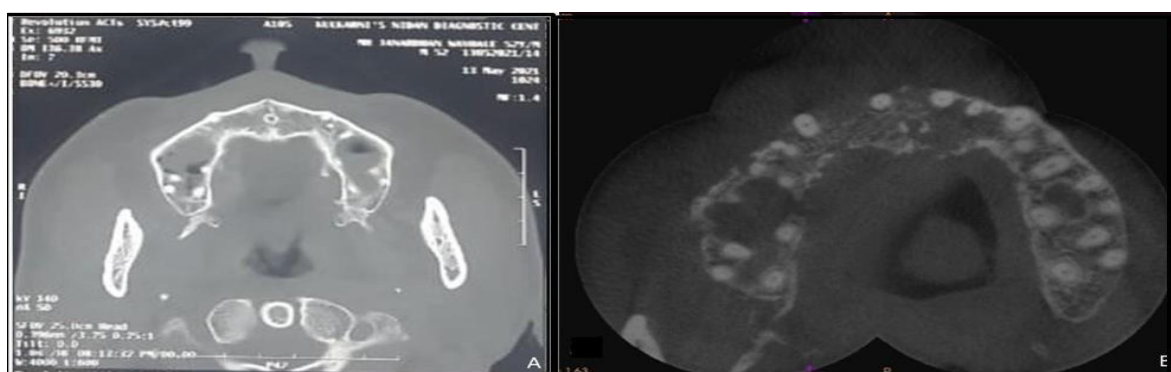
Axial section of CT (bone window) at the level of the maxillary sinus showing opacification of the maxillary sinus. Finer details of the resorption of the bone and the cortices cannot be appreciated. Figure 4B- Axial section of CBCT showing irregular bone loss extending from 21 to 27 and thinning and resorption of buccal and palatal cortical plate noted. (Moth eaten appearance)
